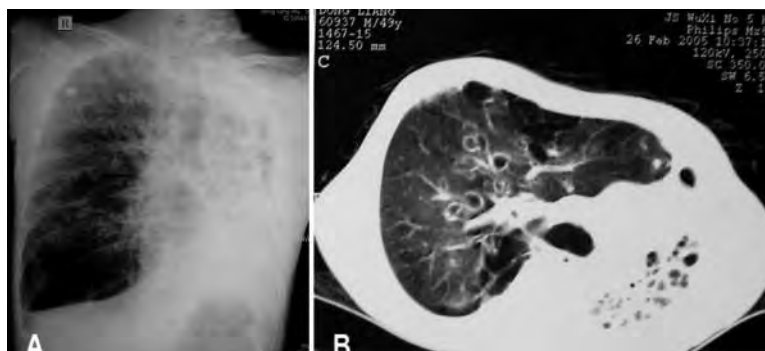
Chest radiograph (A) and CT (B) show left lung diffuse bronchiectasis and right lung bronchiectasis and emphysema with asymmetric thorax.
